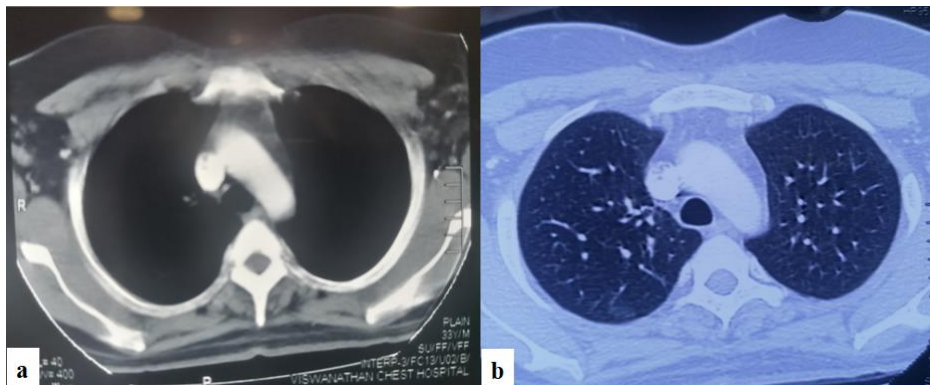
Computed Tomography (CT) scan of the chest after five months showed complete resolution of the mediastinal lymph node and parenchymal lesions.
